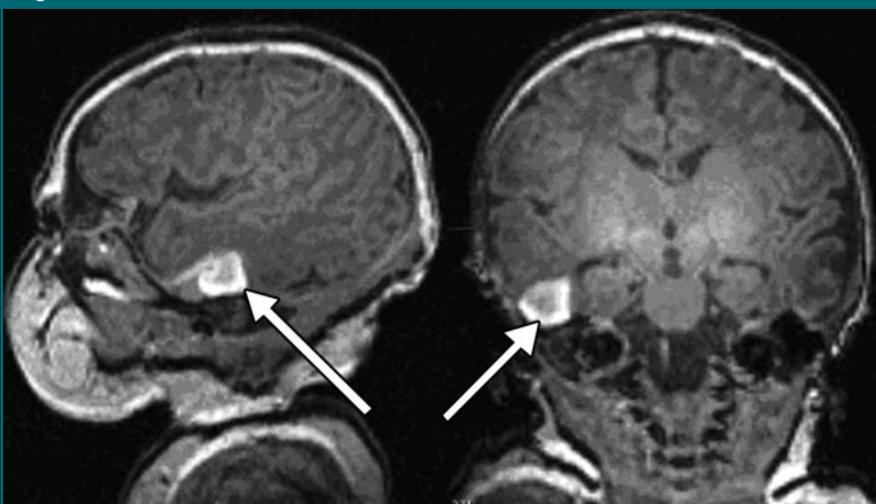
Sagittal (left) and transverse (right) T1-weighted three-dimensional magnetization-prepared rapid gradient-echo MR images (1820/4.38/400; flip angle, 7°; section thickness, 1 mm) in a neonate show intraparenchymal hemorrhage (arrow) in the temporal lobe.
